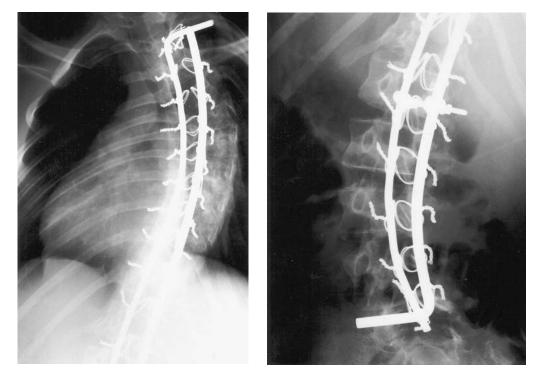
Luque segmental L-rod instrumentation for a child with Friedreich's ataxia. (A,B) PA X-ray films before surgery.
